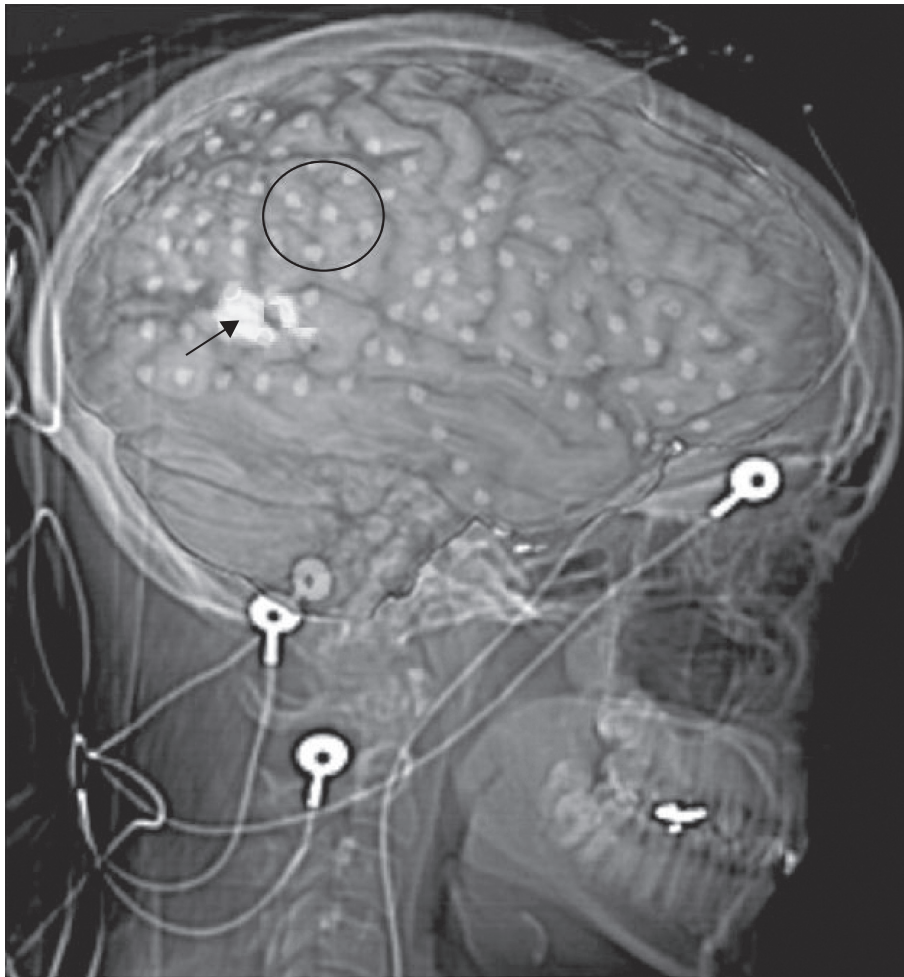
Reconstructed image by fusion of MRI 3.0T epilepsy protocol and skull X-ray to confirm implant placement, using MRIcro 1.40 build 1 program. The reconstructed calcified lesion is shown in white and pointed by the black arrow. Contacts from centro-parietal grids showing ictal discharges (14-15 and 22-23) are circled.
